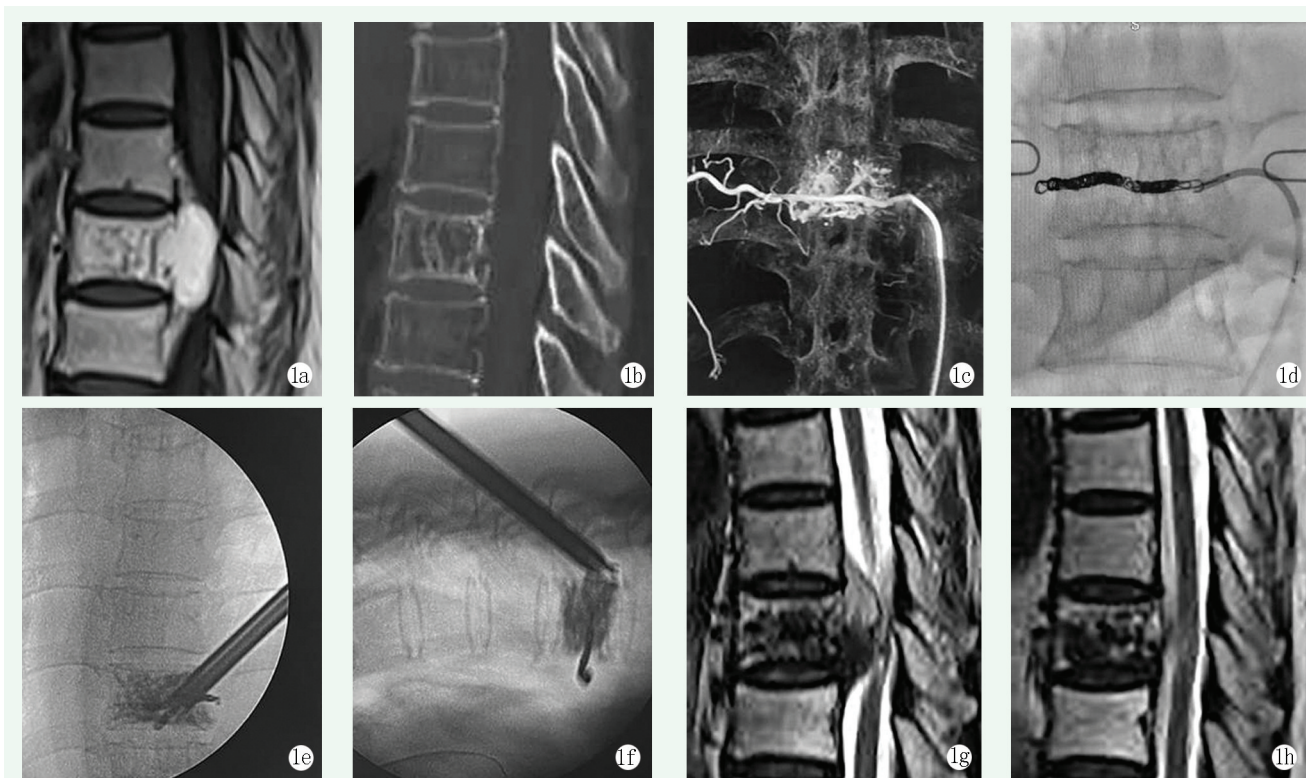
患者女性，58 岁。1a: 术前矢状面增强 MRI 显示椎体后方椎管内占位；1b: 术前矢状面 CT 见椎体垂直方向加厚的骨小梁，呈栅栏样；1c: 术前脊髓血管造影冠状位显示 T₉ 椎体内占位，血供来源于右侧第 9 肋间后动脉；1d: 弹簧圈栓塞右侧第 9 肋间后动脉近端；1e: 术中冠状面透视显示 T₉ 椎体骨水泥填充、椎间孔镜已到椎体中线位置；1f: 术中矢状面透视显示 T₉ 椎体后缘椎间孔镜深度和位置；1g: 术后 1 周复查胸椎 MRI 矢状位提示椎管内血管瘤约 60% 被摘除；1h: 术后 4 个月复查胸椎 MRI 矢状位提示椎管内未完全摘除的血管瘤逐渐皱缩，受压脊髓明显恢复。
